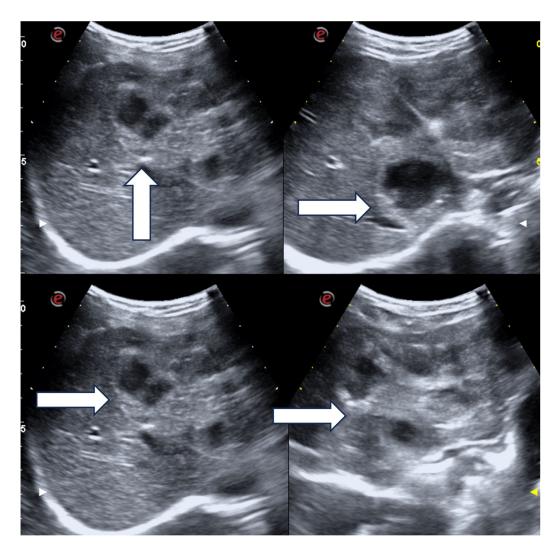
Shows ultrasound images of the liver. There was a conglomerated mixed density lesion involving the left lobe showing anechoic areas within (block white arrows).
